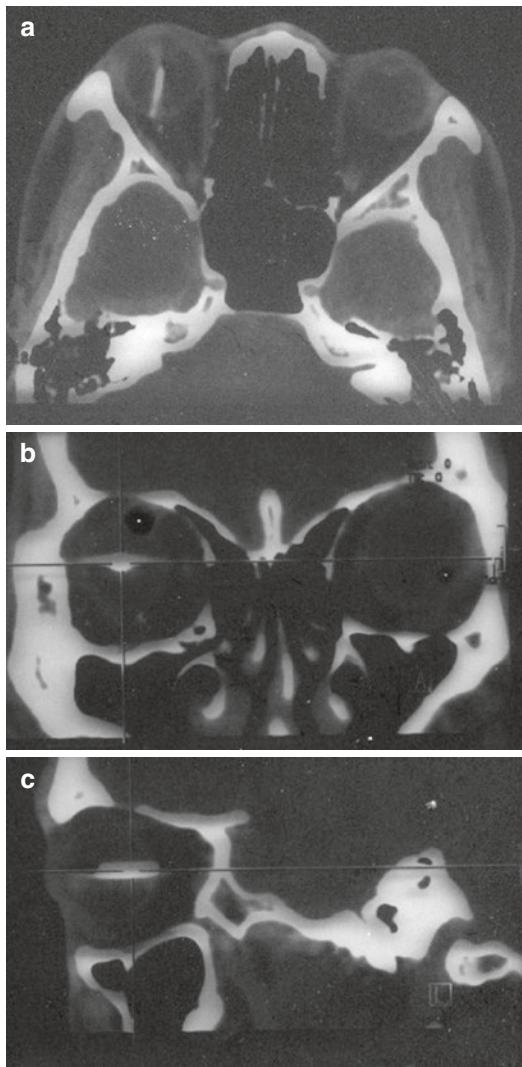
Orbital CT scans of the patient before surgery showing the intraocular foreign body (IOFB) from different angle of the view. (a) The axial CT scan showing destroyed lens and hyperreflective IOFB in the vitreous body and penetrating through the posterior globe wall. (b) The coronal CT scan showing the cross section of the foreign body. (c) The sagittal CT scan showing the IOFB embedded in the posterior globe wall
